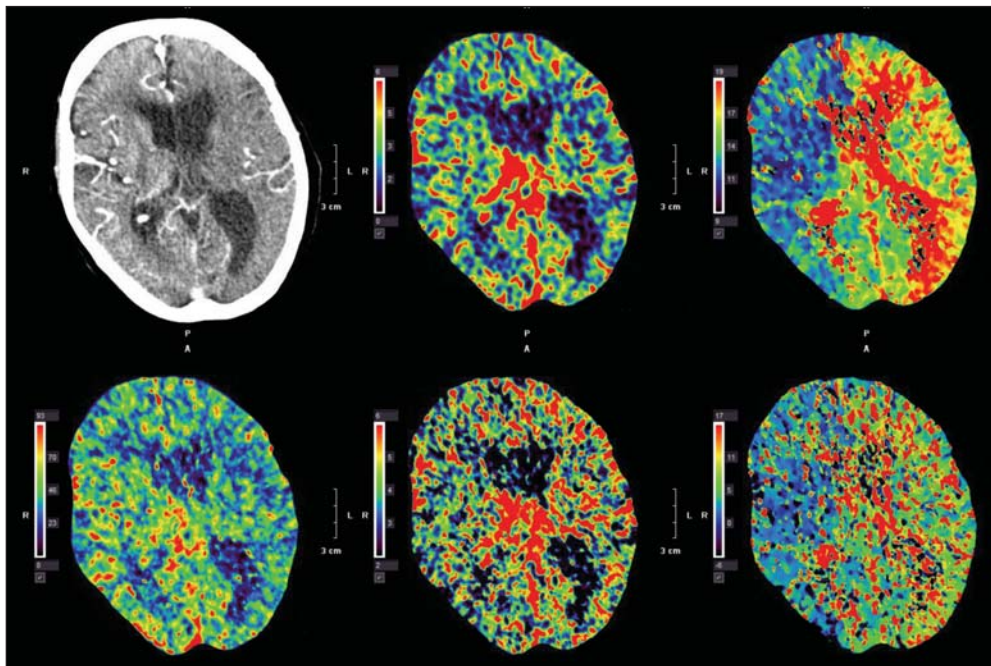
CTP imaging study that is abnormal due to *extracranial* carotid stenosis. The left cerebral hemisphere has increased TTP as demonstrated by the upper right panel. Notice the bottom right image is relatively symmetrical because intracranial flow is normalized to the carotid artery at the skull base. It is imperative during interpretation of imaging to account for possible overestimation of areas of acute ischemic penumbra by evaluating concurrent CTA findings.
